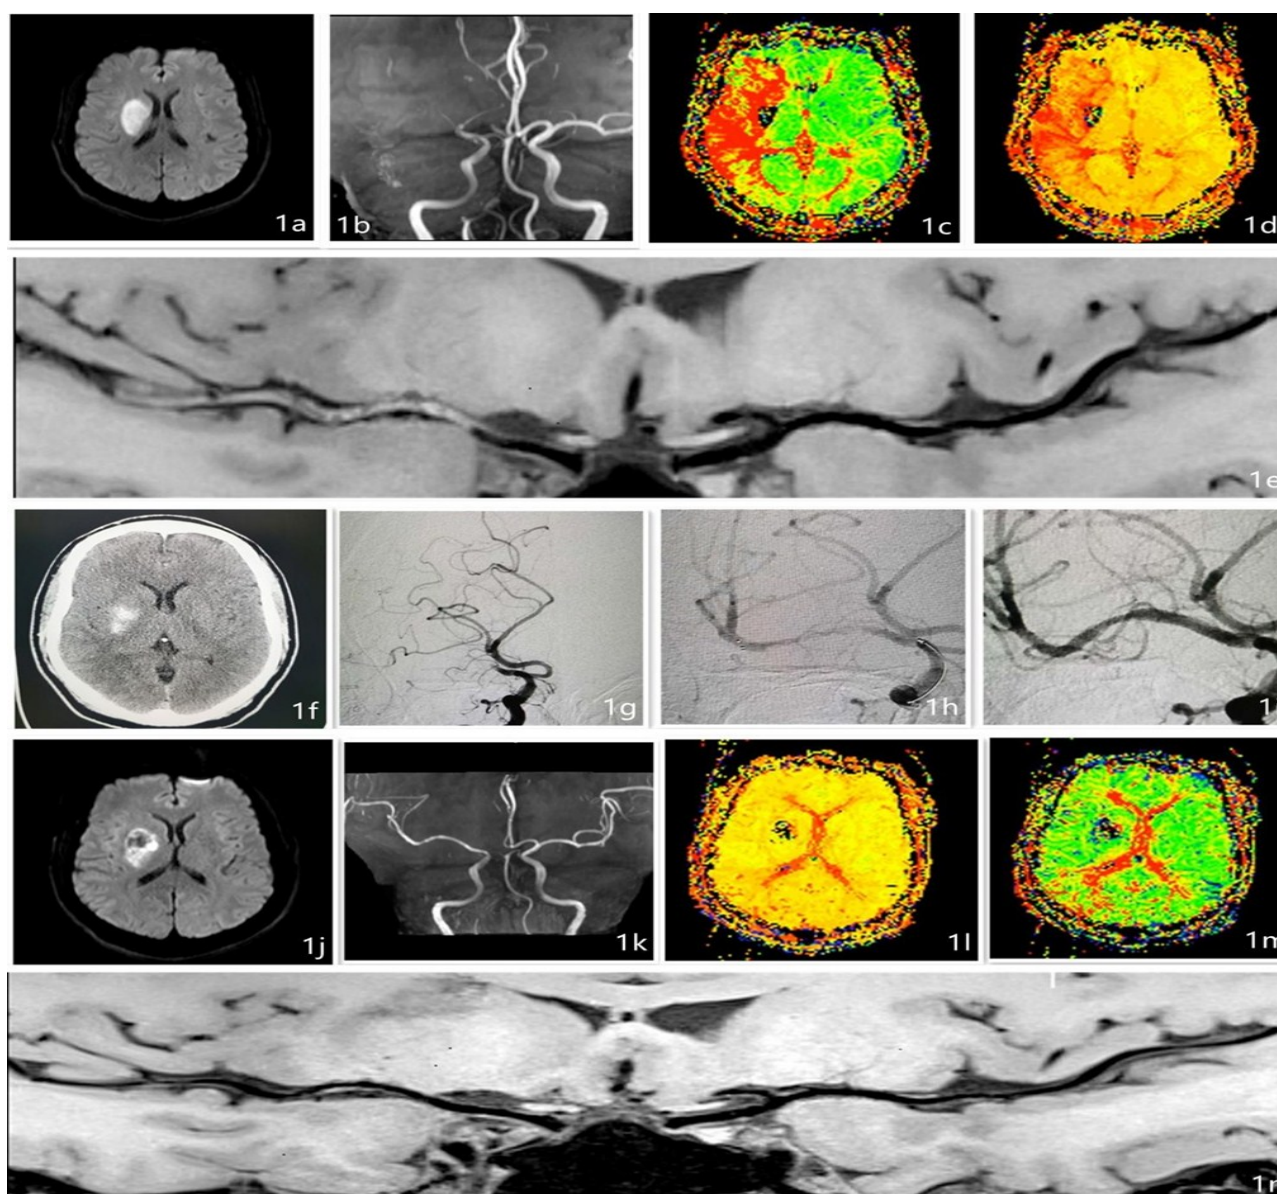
Examples of imaging images in typical cases: (a), is a preoperative MRI non-contrast DWI image; (b), is an MRA image showing right middle cerebral artery occlusion; (c-d), shows MRI perfusion imaging; (e), shows the location of the occlusion and the length of the intravascular thrombus (arrows are located at the proximal and distal ends of the occlusion) on HR-MRI non-contrast scan; (f), shows no obvious bleeding on postoperative CT, and the contrast effusion is considered in the core area of the infarct due to high density; (g-i), are before the opening of the intraoperative blood vessels; (j), shows that the core area of the microinfarct is not enlarged by postoperative MRI DWI images; (k), shows recanalization after right middle cerebral artery occlusion shown by postoperative MRA; (l-m), shows the obvious improvement of ischemia in the right middle cerebral artery supply area on postoperative MRI perfusion images; and (n) shows the patency of the lumen of the occluded vessel by HR-MRI after non-contrast HR-MRI.
